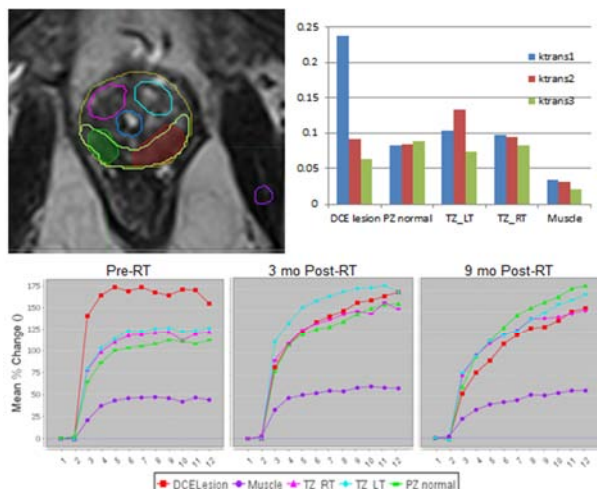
Evaluation of treatment response using MP-MRI pre- and post-RT for a patient in the experimental arm of HEIGHT. ROIs are outlined in 3 dimensions: prostate (orange); peripheral zone (PZ) – yellow; dominant tumor – red; normal PZ – green; urethra (blue); left (light blue) and right (pink) transition zone (TZ); muscle (purple). Below: DCE curves for ROIs pre-Tx, and 3 & 9 mo post-RT. K^{trans} (upper right corner).
